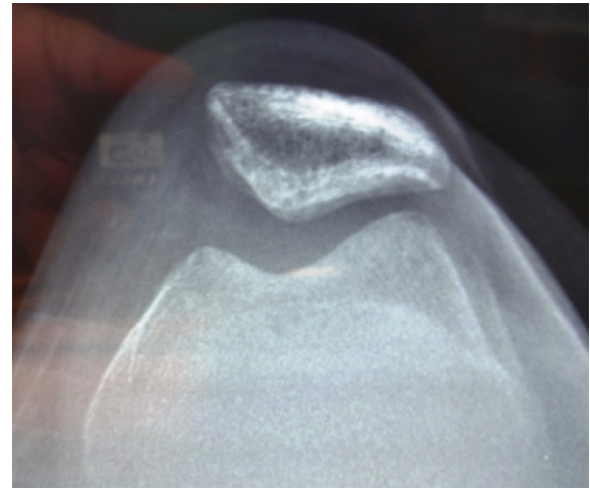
Radiograph image showing opening of patella- femoral joint space.
